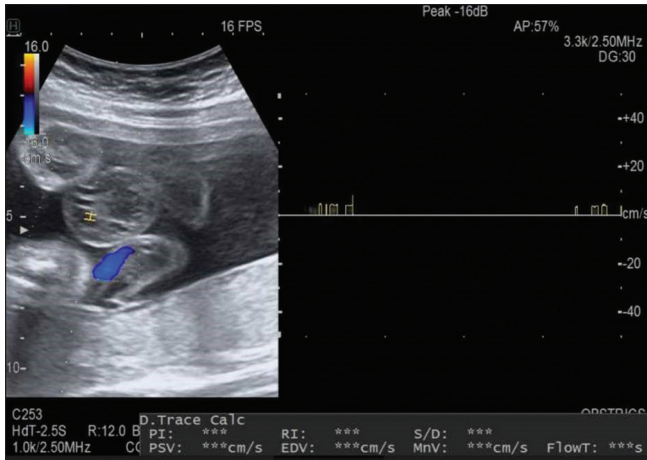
Umbilical vein Doppler showing absent waveform suggesting thrombosis
